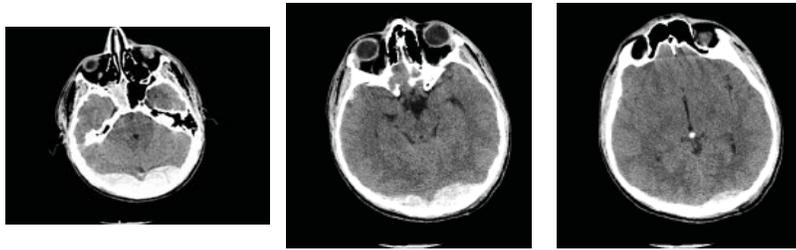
The follow up CT Brain done for case No.1 after 12 hours. (a) showed an enlargement of the right EDH and a newly seen left retro cerebellar acute EDH. (b) the CT cut just above the tentorial hiatus at the level of midbrain showing the supratentorial extension of the hematomas in both sides. (c) Higher cut at the level of the 3rd ventricle showing the final superior extent of the Lt acute EDH
